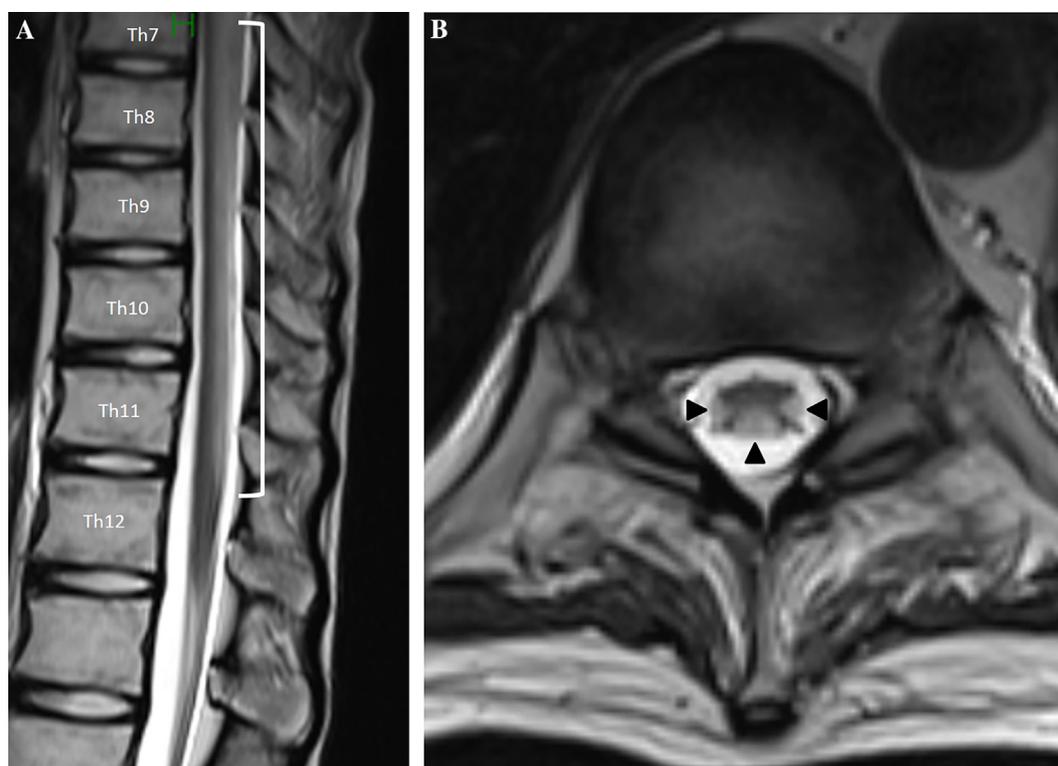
(A) Spinal magnetic resonance imaging (MRI) sagittal T₂-weighted image (T2WI) showing diffuse hyperintensity in the posterior spinal cord at Th7–12 and (B) spinal MRI axial T2WI image showing symmetrical hyperintensity in the posterior and lateral spinal cord (arrows heads).
